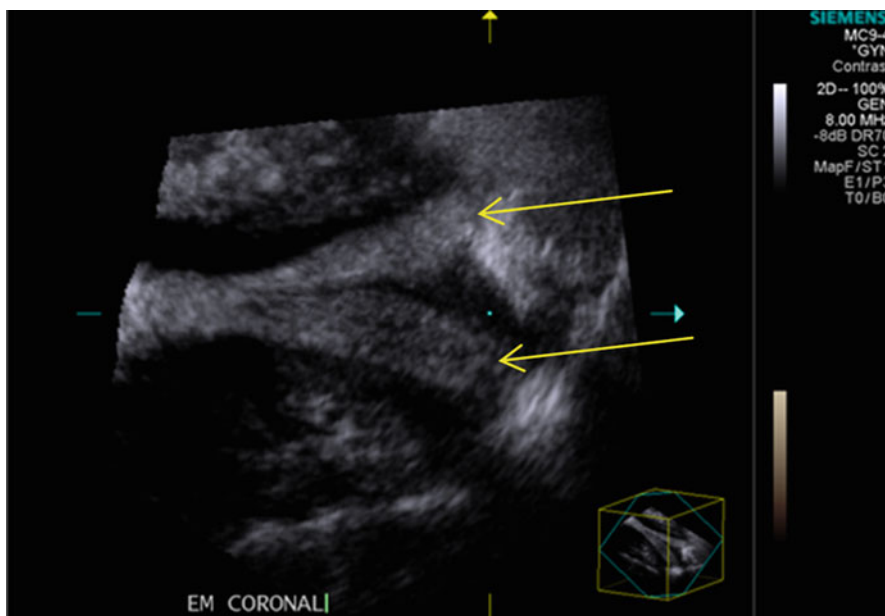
Three-dimensional ultrasound imaging.* Multi-planar reformatting of the uterus demonstrating the two uterine horns (arrows) in a didelphys uterine malformation
